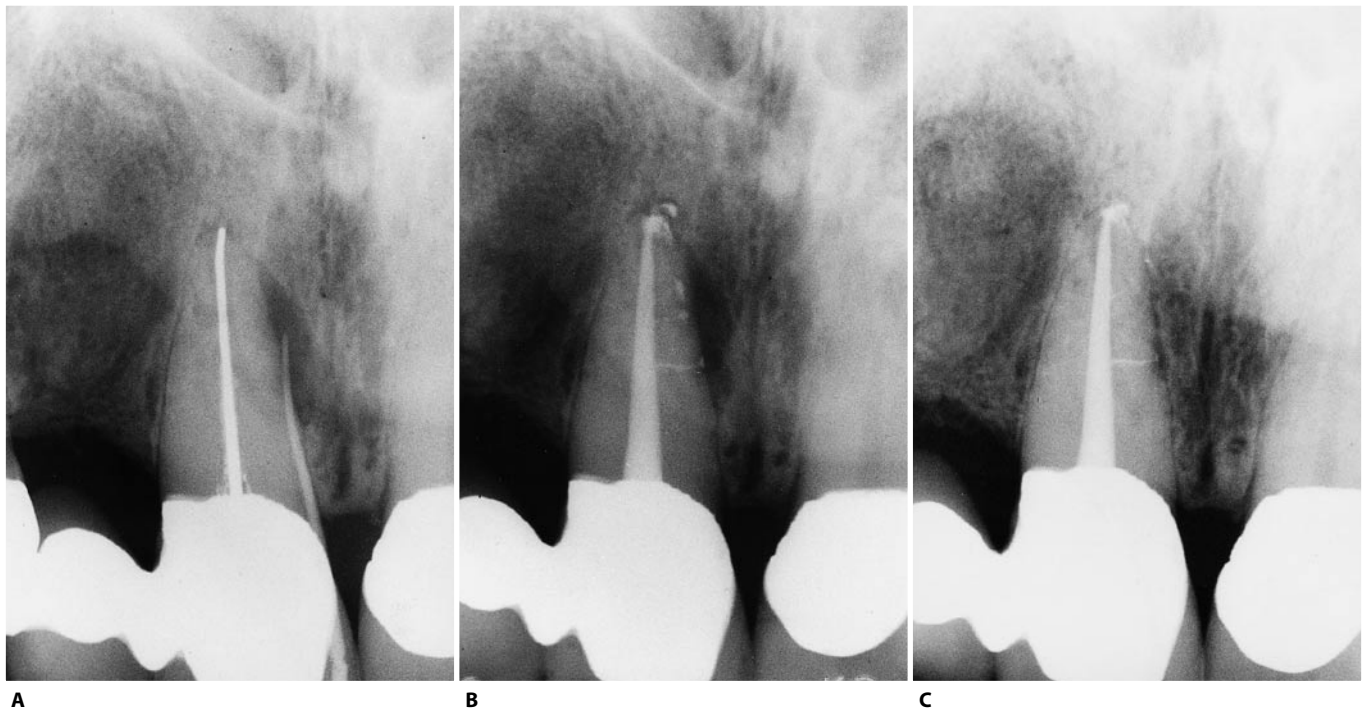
Nonsurgical retreatment of the maxillary central incisor, which has already been treated with a silver cone. The mesial radiolucency is a contraindication to the surgical approach. A. Preoperative radiograph: a gutta percha cone has been introduced into the fistula and reaches the lesion on the side of the root. B. The postoperative radiograph shows that the lesions had been maintained by three lateral canals that had not been filled. C. The one-year recall shows the healing (Courtesy of Dr. C. J. Ruddle).
